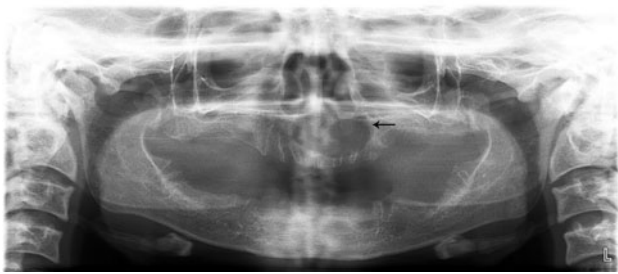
Orthopantomograph showing well-defined, ovoid, radiolucent area in midline of anterior maxilla
